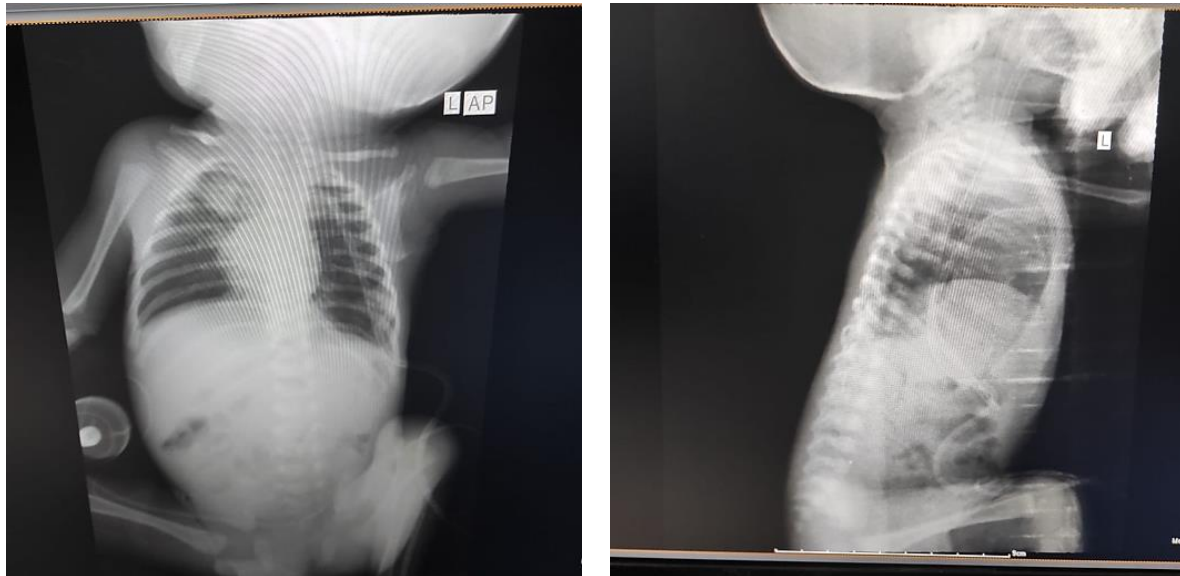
Postoperative anteroposterior (AP) and lateral (L) chest X-ray
